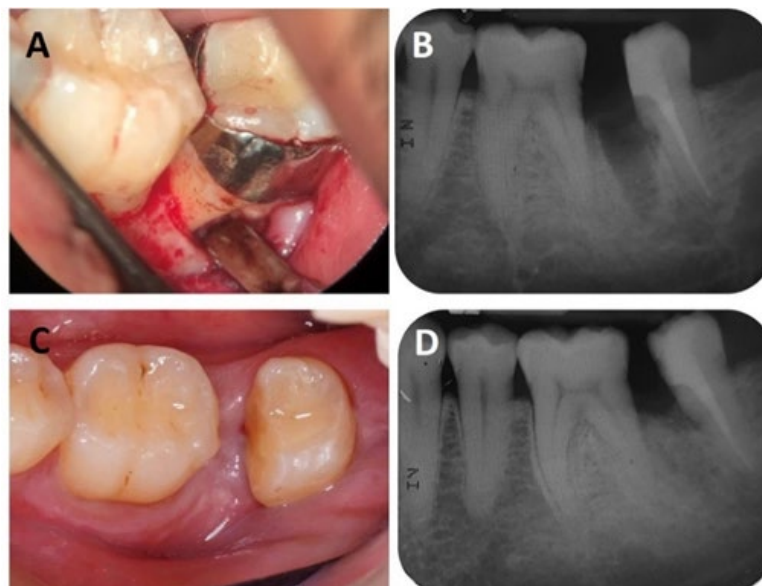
Hemisection of tooth 37. A: Envelope flap raised on buccal and lingual gingiva prior to hemisection. B: Post-hemisection radiograph, showing overhanging dentine at furcation area mesial to the remaining tooth segment and absence of periapical radiolucency on the remaining root. C: Clinical photograph 6 months post-hemisection showing healed soft tissue and clean mesial hemisected surface. D: 6 months post-hemisection radiograph showing mesial drifting of the distal tooth segment and healed bony lesion.
